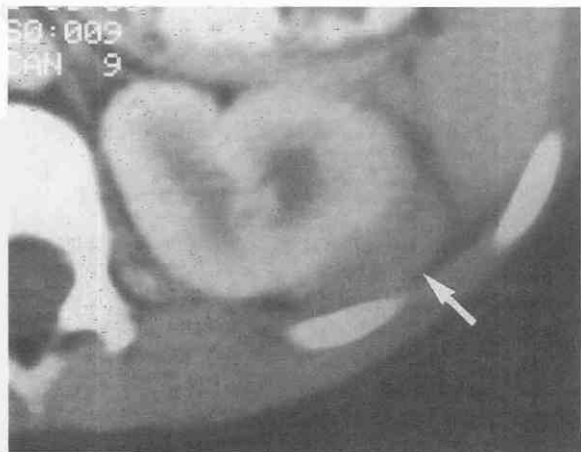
A hyperplastic intralobar nephrogenic rest presents as a low-density subcapsular mass (arrow) on a contrast-enhanced CT scan.
